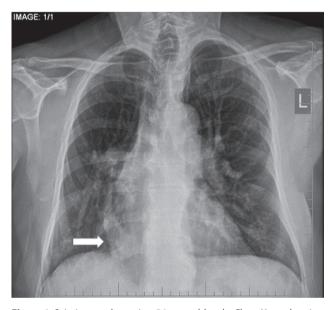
Scimitar syndrome in a 56-year-old male: Chest X-ray showing the anomalous draining vein as a tubular structure paralleling the right heart border in the shape of a scimitar (Turkish sword) (white arrow).
